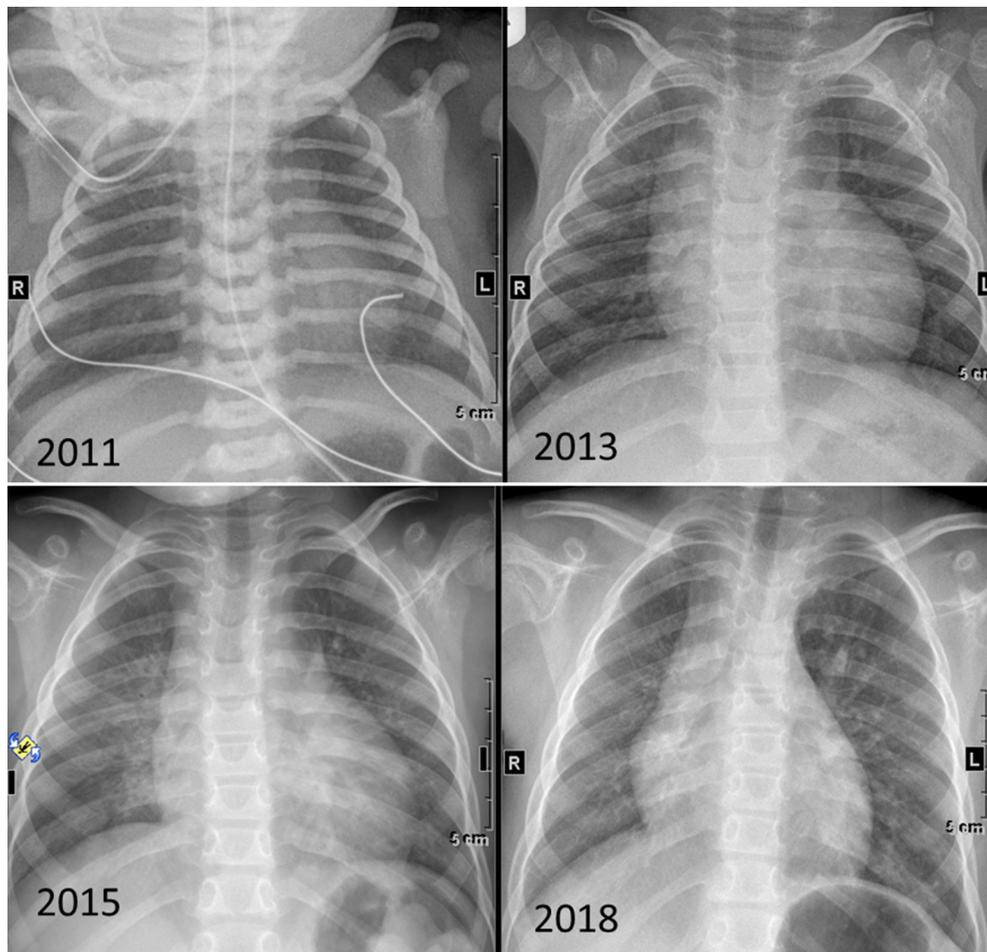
Serial frontal chest radiographs from birth (top right) to age 7 years (bottom left). While the initial film shows normal symmetry of the hila and lungs, over time asymmetry of the lungs as well as the hila is apparent, with the right side smaller than the left.
